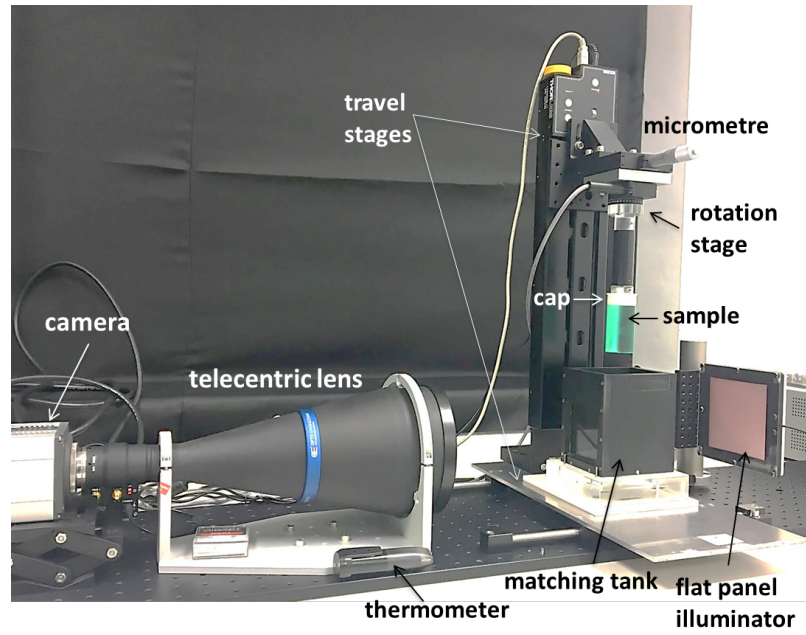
Telecentric optical-CT scanner.
